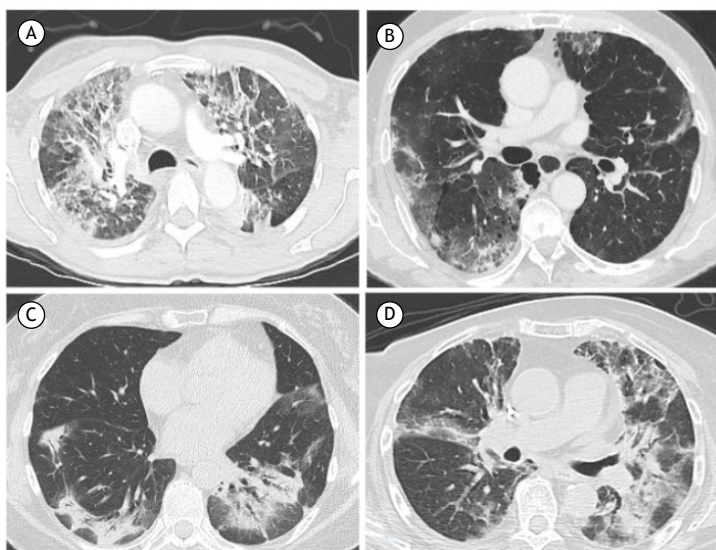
In A, axial CT scan showing pulmonary ground-glass opacities and organizing pneumonia, predominantly in the upper lobes, in a female patient with squamous non-small cell lung cancer using docetaxel. In B, CT showing ground-glass opacities overlapping with areas of emphysema, particularly in the right lower lobe, in an elderly patient with lung cancer using pembrolizumab. In C, CT scan showing bilateral areas of consolidation in the lower lobes, consistent with organizing pneumonia, in a 62-year-old female patient with melanoma under treatment with nivolumab plus ipilimumab. In D, axial CT scan shows ground-glass opacities and consolidations suggestive of organizing pneumonia in middle and upper lobes in a patient with breast cancer treated with trastuzumab-deruxtecan.
